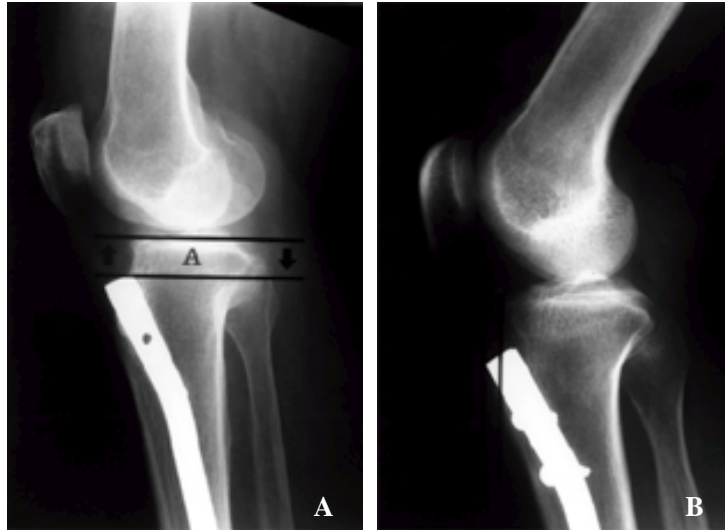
Postoperative lateral radiograph of knee demonstrating technique of measuring (A) Nail plateau distance (B) Extent of nail protrusion beyond anterior tibial cortex.
